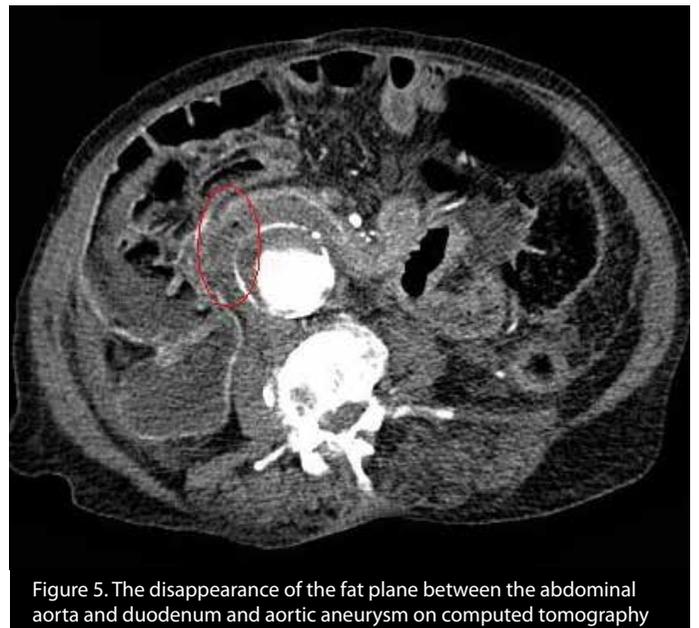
The disappearance of the fat plane between the abdominal aorta and duodenum and aortic aneurysm on computed tomography
